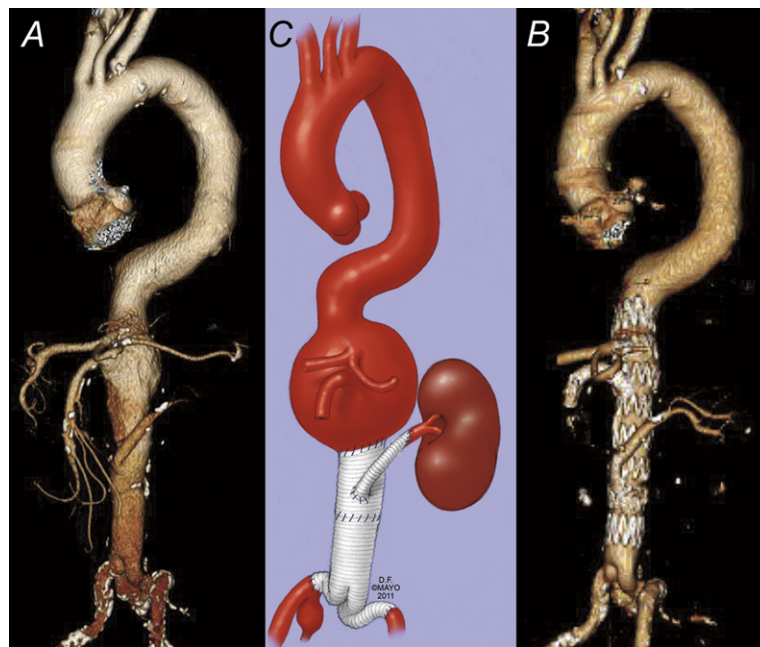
Computed tomography angiography shows a 10-cm type IV thoracoabdominal aortic aneurysm (A) on a patient with prior aortic repair and left renal artery bypass graft (B). Repeat computed tomography angiography after urgent endovascular repair with modified fenestrated endograft showed successful aneurysm exclusion, no endoleak, and patent branched stent grafts (C).
